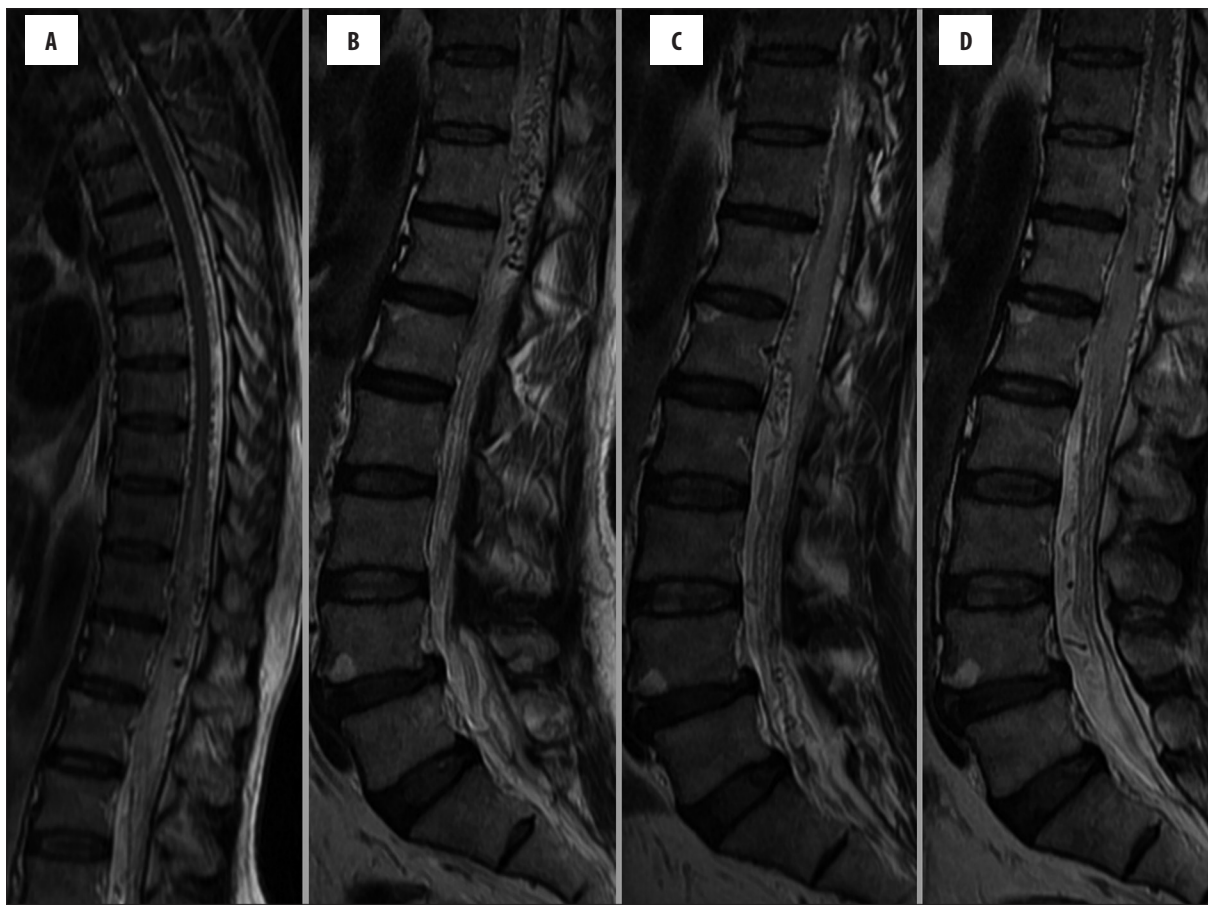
Sagittal T2-weighted (TR=3000 ms, TE=88 ms) images (A–D) of the spine demonstrate bulky lower dorsolumbar cord and conus medullaris with increased signal intensity and multiple intradural extramedullary areas of signal void. Grade 1 anterolisthesis of L4 over L5 vertebral body is noted.
